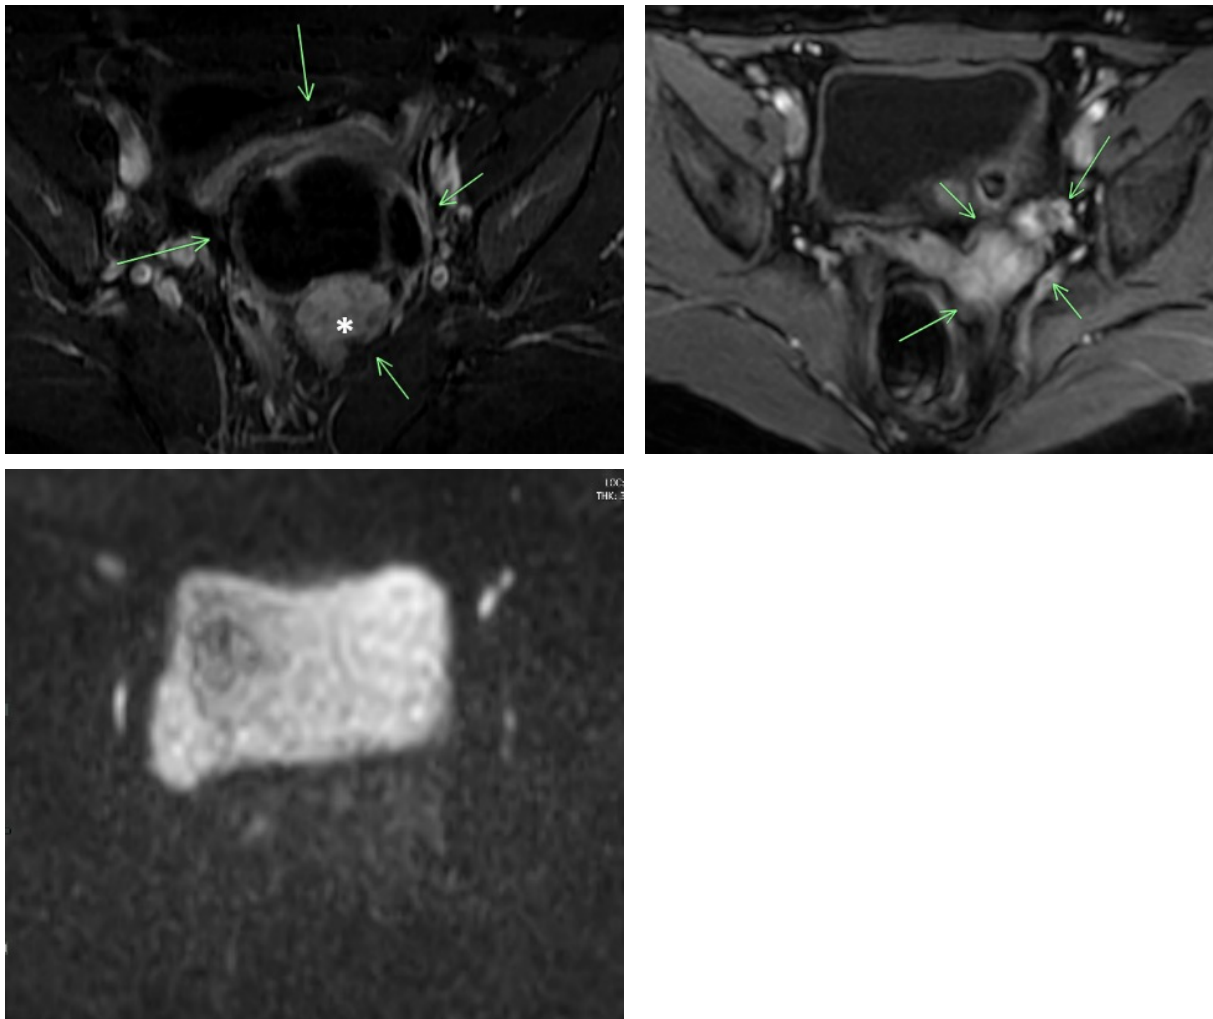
1.5 Tesla MRI scan of the pelvic cavity. Before treatment with GnRH (A), a complex pelvic mass was observed. After treatment, there was, an interval decrease in size, with a residual enhancing solid component in the left pelvic cavity on the post-contrast subtraction image (B). There is no evidence of restricted diffusion (DWI B=800) within the enhancing solid nodule (C).
